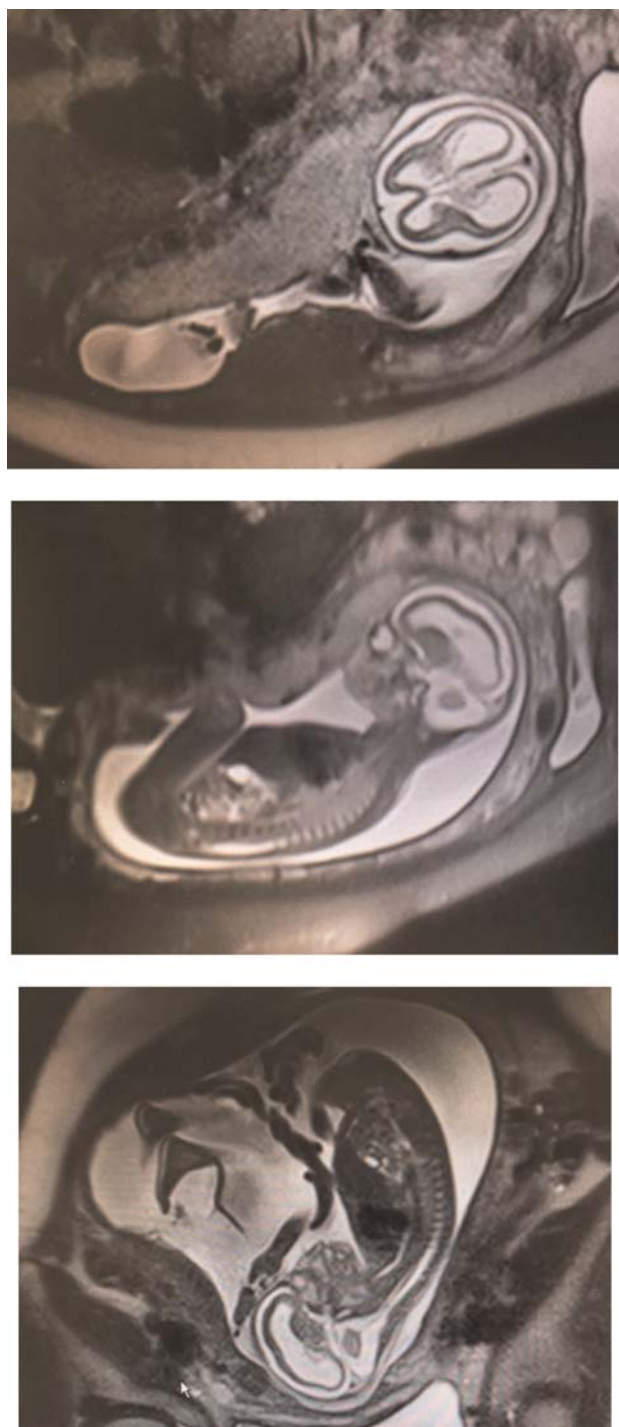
Fetal MRI showing bilateral mild ventriculomegaly, partial collapsed skull, and severe atrophy in the fetal brain.
